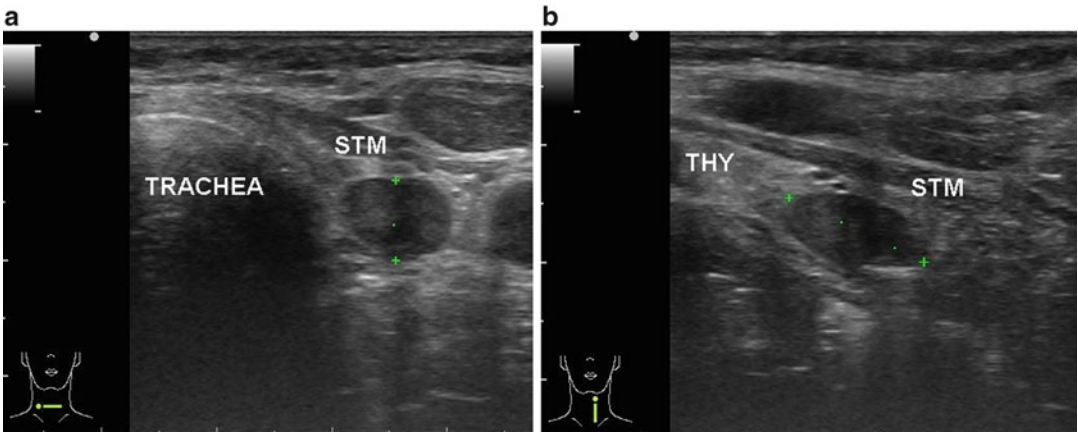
Typical sonographic appearance of an enlarged lower parathyroid gland in transverse (a) and longitudinal (b) views. It is located inferior to the lower
